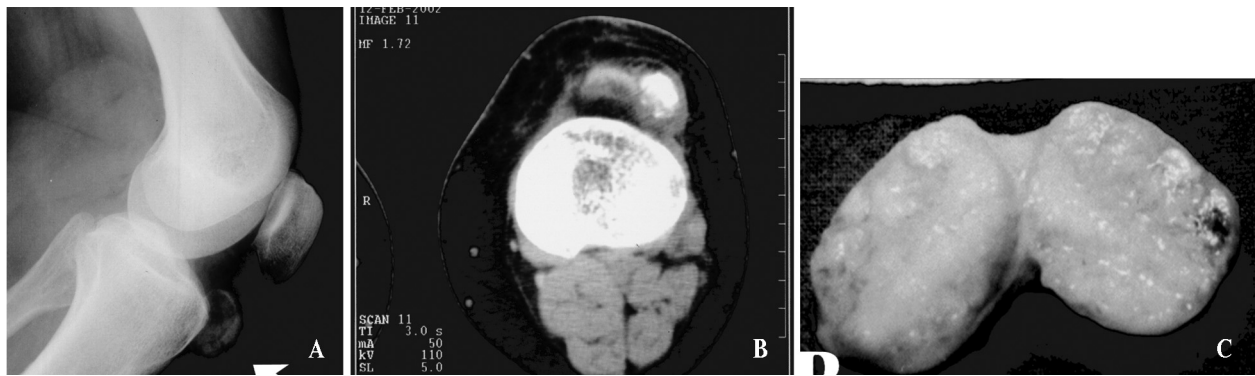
A. Lateral radiograph of the right knee: large infrapatellar ossified mass. B. CT scan of the same knee: encapsulated ossified mass. C. Macroscopic appearance of the excised tumour on cross-section.*
